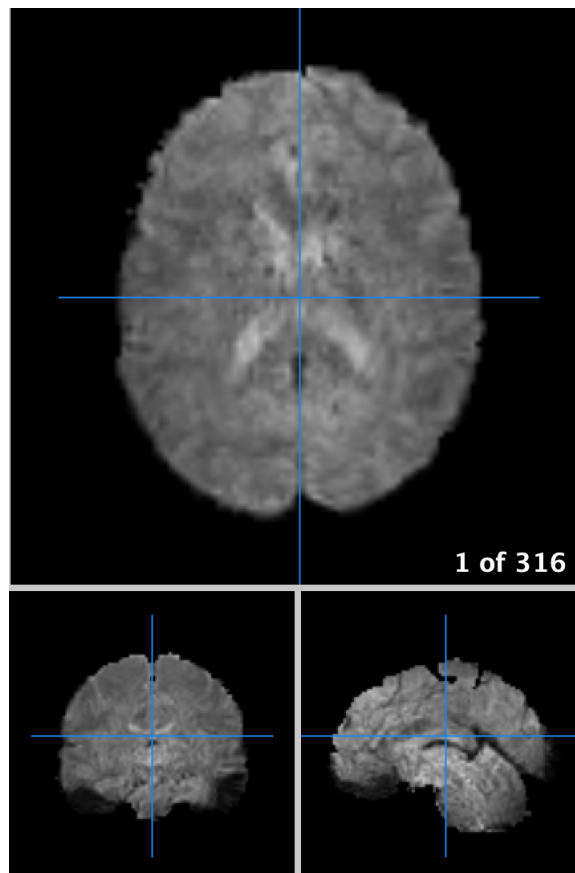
An example of a T_2^* -weighted (or BOLD contrast) image obtained from an MRI from dataset in (Glasser et al., 2013)
